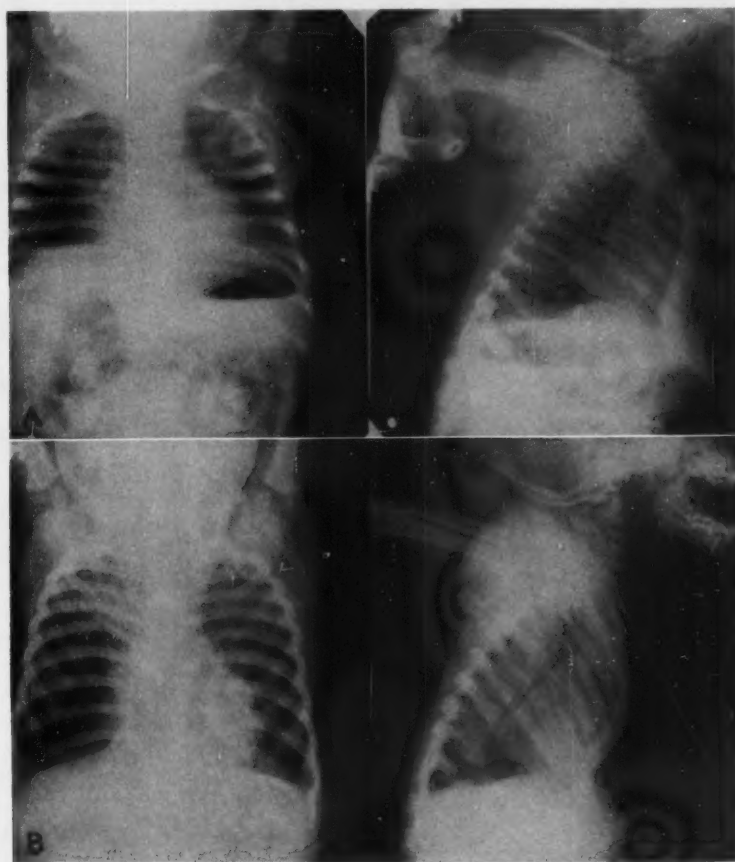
(A) Roentgenograms show a mild pectus excavatum deformity in an eleven-month-old girl. (B) The same child a year later at twenty-three months of age shows marked increase in severity of the pectus excavatum as well as bilateral upper lobe pneumonic infiltrations.
